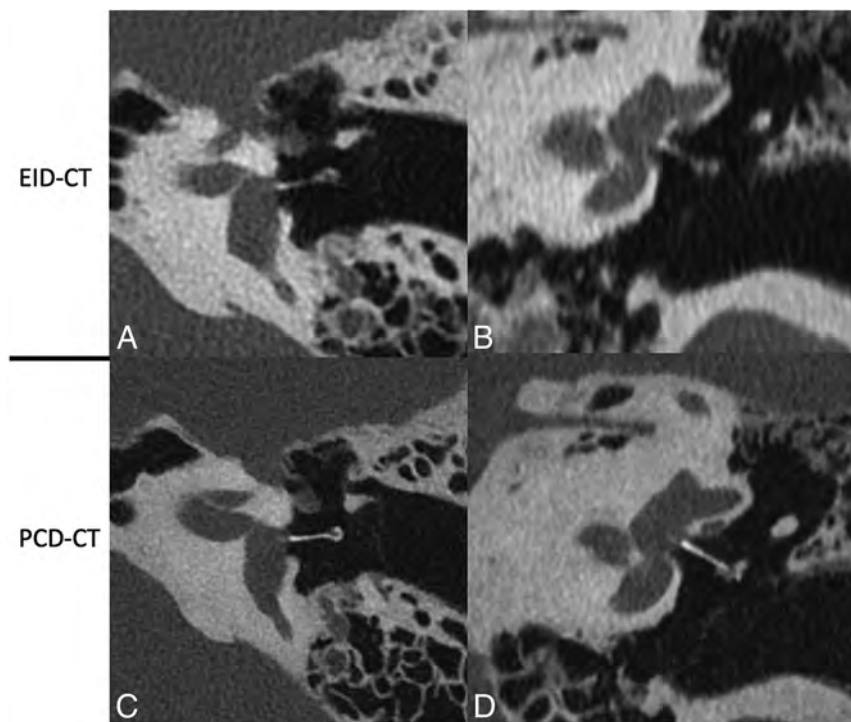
A stapes piston prosthesis shown on EID-CT (upper row) and PCD-CT (lower row) images. The prosthesis is shown on oblique axial (A and C) and oblique coronal (B and D) reformats along the plane of the piston. In both planes, the stapes prosthesis was better delineated on PCD-CT due to reduced partial volume averaging from 0.2 mm sections. These additional reformatted images were generated by a nonreviewer radiologist to demonstrate certain anatomic features but were not used by the readers to score image quality.
